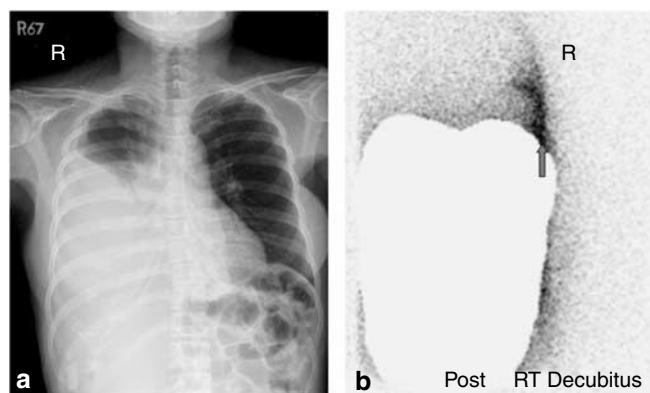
CAPD-related hydrothorax. (a) Chest X-ray showing massive right side pleural effusion and (b) Tc-99m peritoneal scintigraphy showing tracer uptake over the right side of the diaphragm (arrow) after Tc-99m IP injection.
